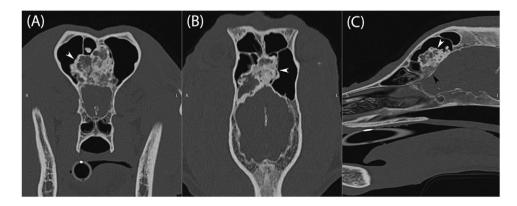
Transverse (A), dorsal (B), and sagittal (C) bone-window survey CT images showing a large, well-defined, heterogeneously mineral attenuating, lobulated frontal sinus mass (white arrow). Mild ventral and caudal displacement of the underlying calvarium is seen (black arrow). A, B, Left is to the right of the image.
